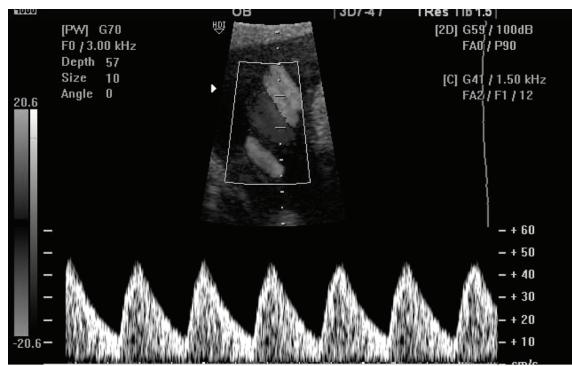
Doppler study of umbilical artery
